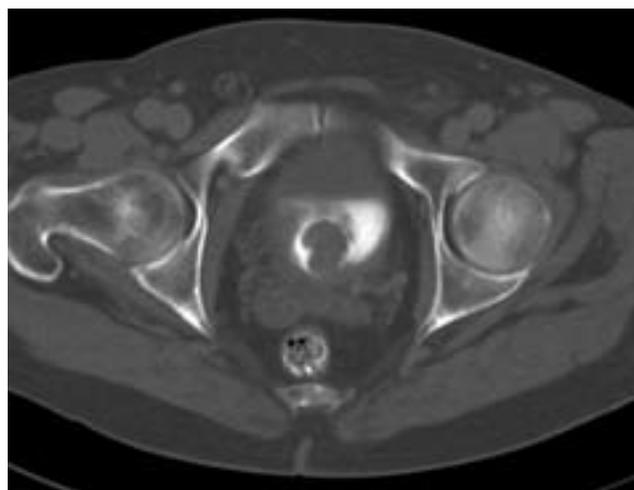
CT demonstrates a round, lobulated mass against backdrop of bright contrast material in the bladder. Biopsy demonstrated transitional cell carcinoma.
